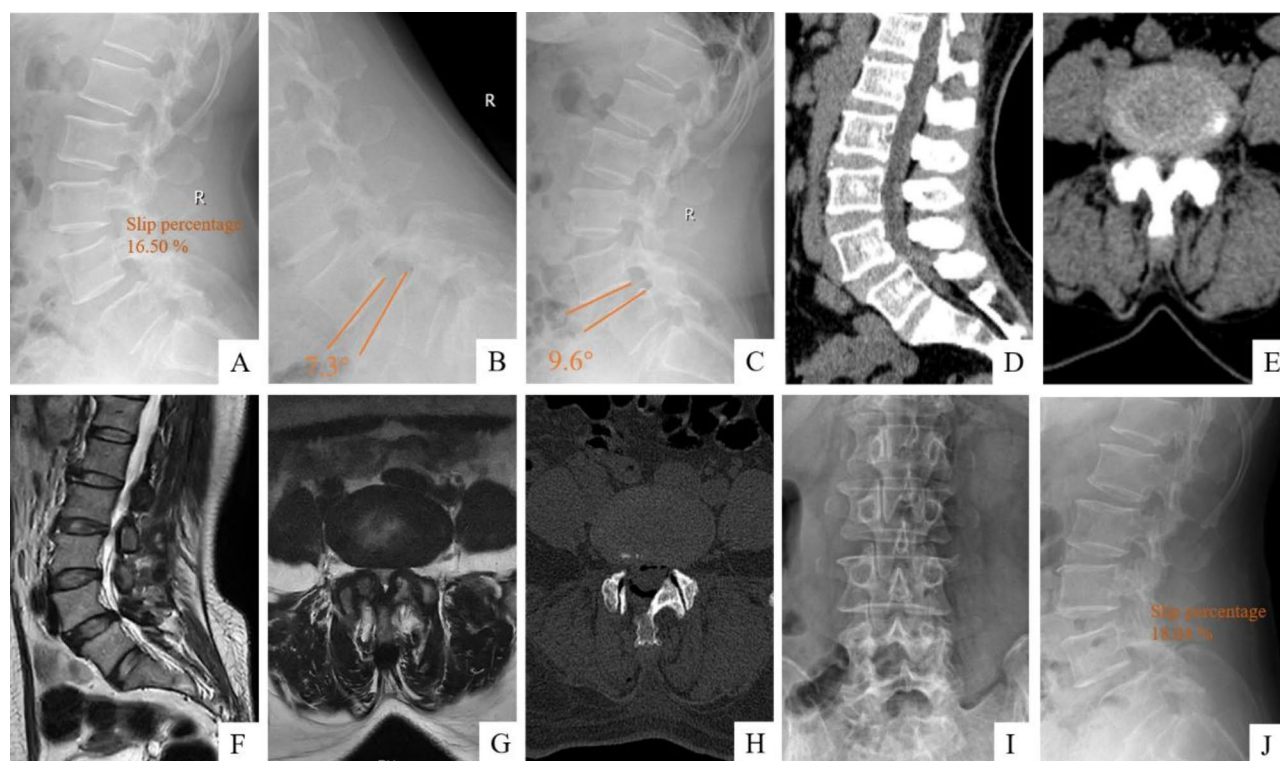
A 51-year-old woman had disc herniation and spinal stenosis at L4/5 and concomitant stable grade I degenerative L4 spondylolisthesis underwent unilateral biportal endoscopic discectomy and decompression at L4/5. Preoperative upright lateral (A) and flexion-extension lateral (B, C) X-ray, sagittal (D) and axial (E) images on computed tomography (CT), and sagittal (F) and axial (G) images on T2-weighted magnetic resonance imaging. Postoperative axial (H) image on CT. Anterior-posterior (I) and lateral (J) X-ray at 16-month follow-up
